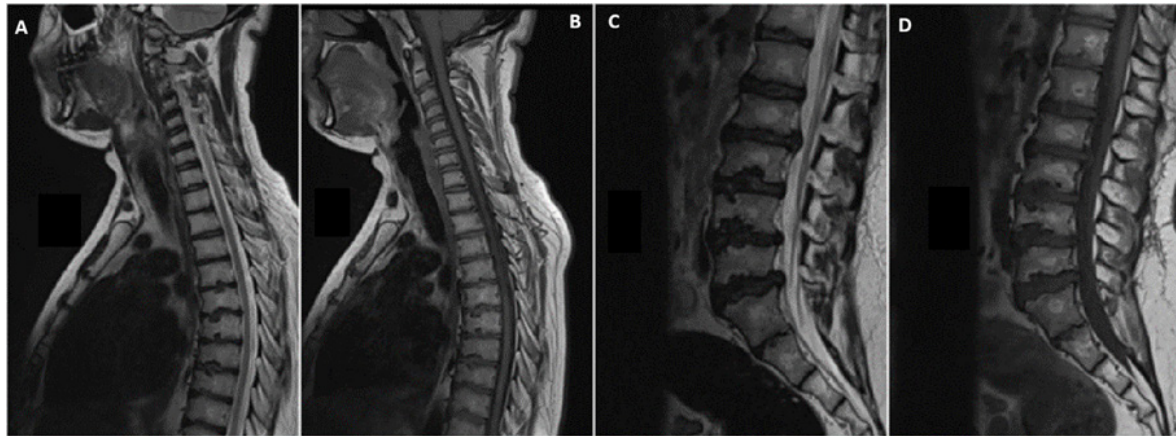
Sagittal T1- and T2-weighted MRI of the cervico-thoraco-lumbo-sacral spine demonstrating multilevel abnormalities from D5 to S2, including central fatty degeneration of the vertebral bodies, anterior wedging, disc space narrowing, and intravertebral herniations (Schmorl's nodes). A: upper T2-weighted image; B: upper T1-weighted image; C: lower T2-weighted image; D: lower T1-weighted image.
